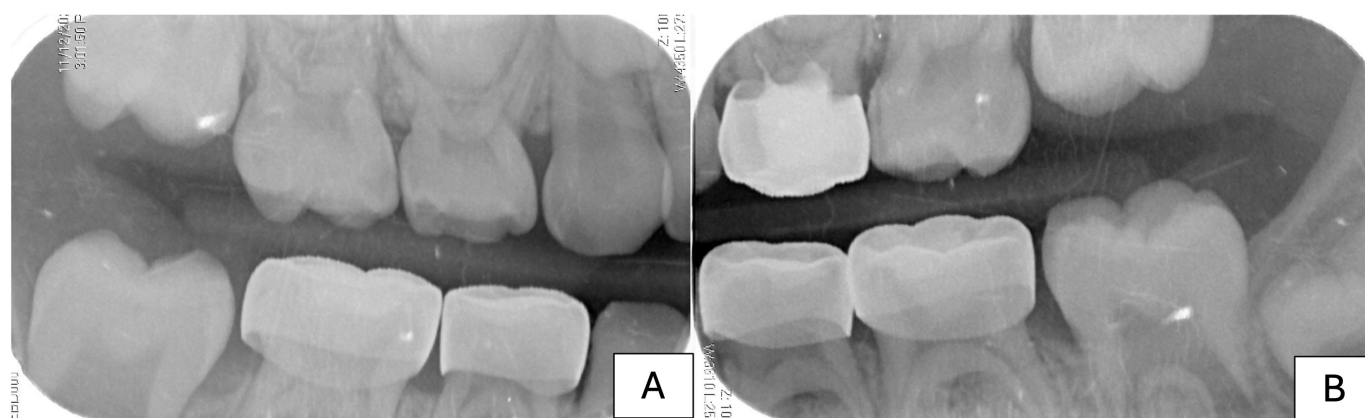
The intraoral bitewing radiographs of the patient after receiving dental treatment. (A) Right intraoral bitewing, showing SSC on teeth #84 and #85. (B) Left intraoral bitewing, showing pulpotomy and SSC on tooth #64, and SSC on teeth #74 and #75.
